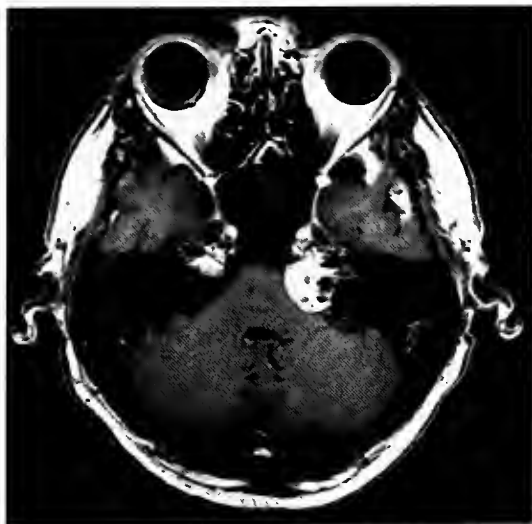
MRI scan of 2.9 cm left cerebropontine angle acoustic neuroma in a patient with vertigo and progressive hearing loss. Following stereotactic radiosurgery (18 Gy to 80% isodose line), the patient showed symptomatic improvement.
